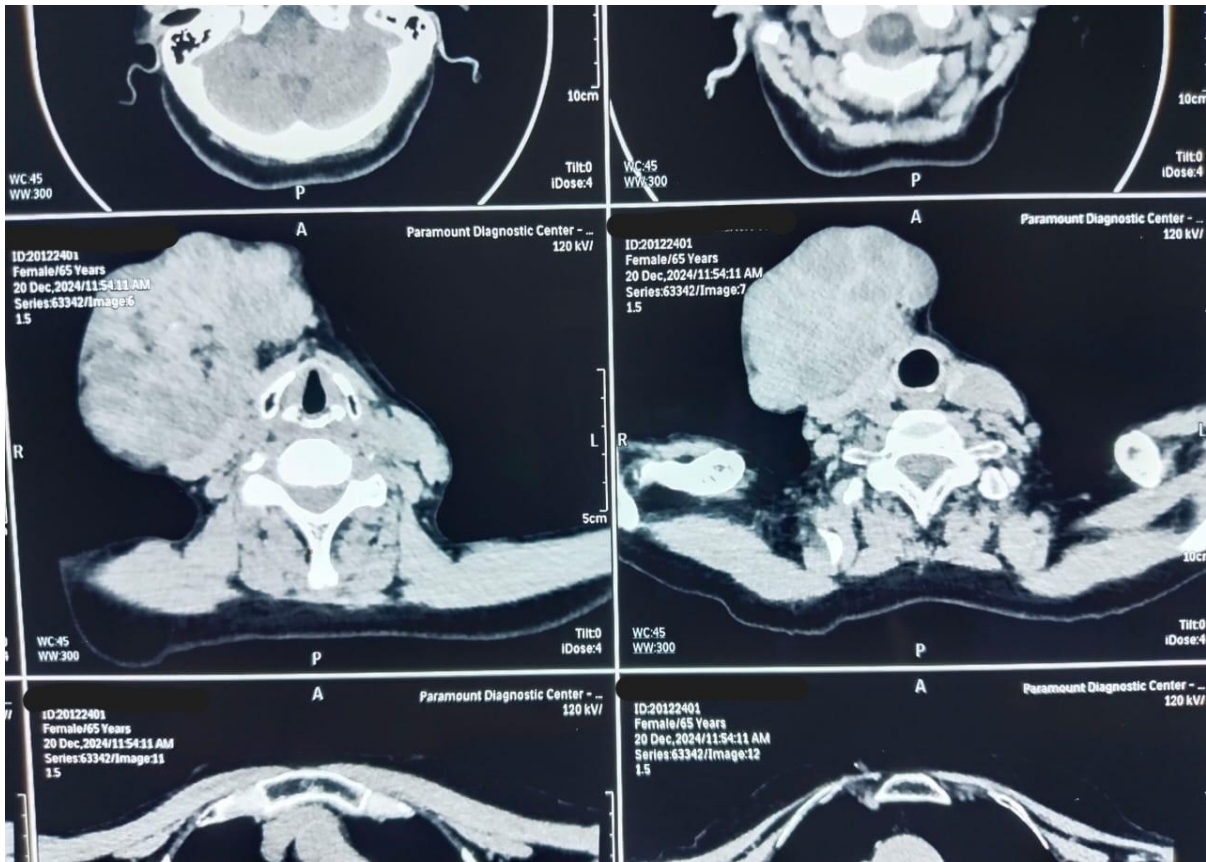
Computed Tomography with contrast of Head and Neck
